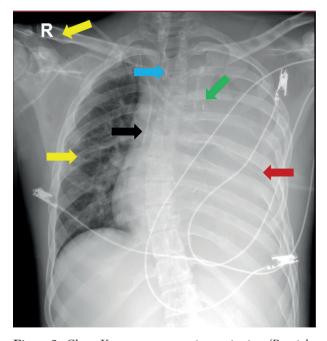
Chest X-ray, anteroposterior projection (R= right side). The trachea deviates to the right (blue arrow), with a non-evaluable cardiac silhouette. Compared to the previous X-ray, there is a marked increase in opacification of the left hemithorax due to pleural effusion, with underlying lung alterations unable to be ruled out (red arrow). Multiple metallic clips from a previous operation are projected onto the midline and mediastinum (green arrow). Right subclavian catheter with its tip projected into the superior vena cava (black arrow). No signs of pneumothorax are present. Multiple hypodense lesions with a lytic appearance are observed in the clavicle, scapulae, and rib cage (yellow arrow).
